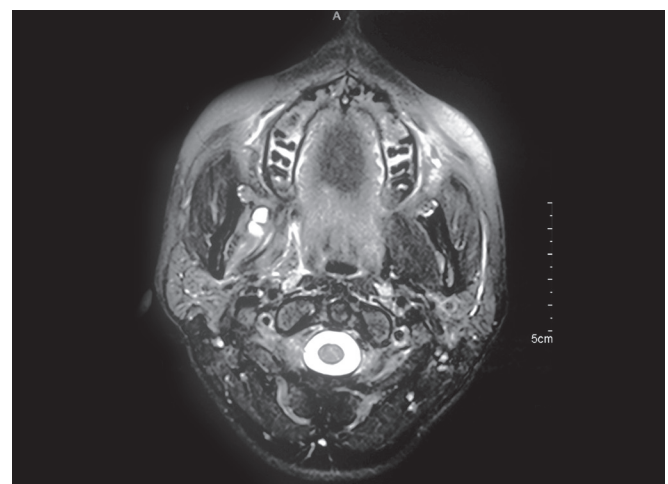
Magnetic resonance imaging showing a bulky right lateral pterygoid muscle with mild altered signal intensity likely due to inflammatory change
